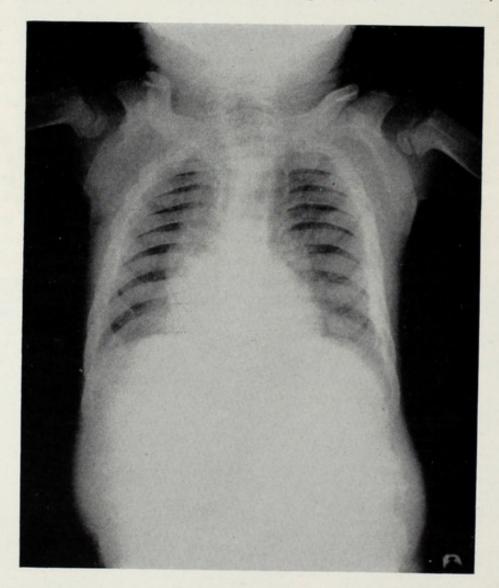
Chest x-ray film of G. V. D., Jr. (B2188), 4½ years of age. This patient has the Hurler syndrome in entirely typical form. He reached a peak of intellectual development at about 2 years and has deteriorated since then. Gibbus was noted at 1 year. Thick skin, lanugo, "shoe-shaped" sella, and ground-glass corneas are present. Hydrocele and right inguinal hernia were treated surgically at the age of 1½ years.
